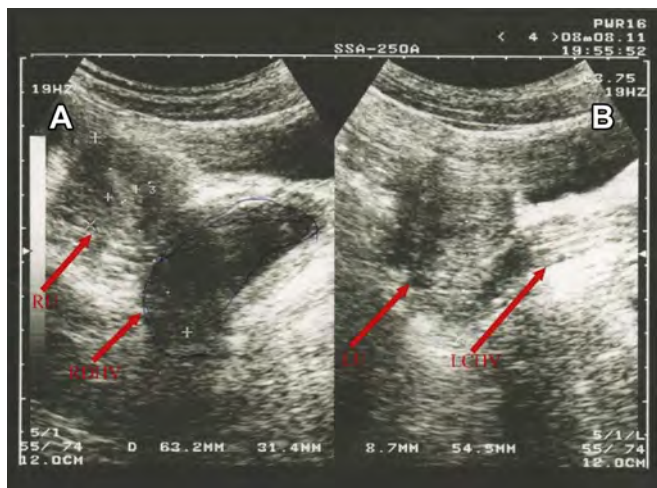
Sonographic image, transverse view of (A) right uterine cavity with endometrium appearing normal and a cystic hypoechoic lesion, located anterior to the cervix, and (B) normal left uterine cavity and endometrium. LCHV = left collapsed hemivagina; LU = left uterus; RDHV = right distended hemivagina; RU = right uterus.
